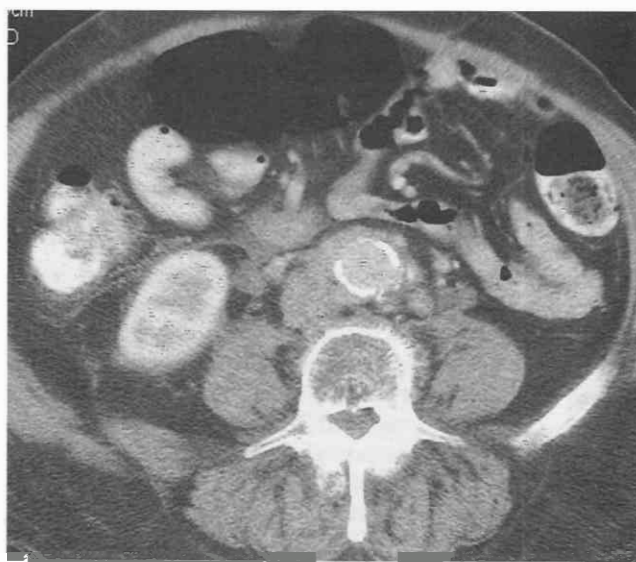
Retroperitoneal lymph node metastases mimicking retroperitoneal fibrosis. Contrast-enhanced CT scan demonstrates a conglomerate soft tissue mass of lymph nodes enlarged by tumor that surrounds the partially calcified abdominal aorta in a 75-year-old man with metastatic prostate cancer. The CT appearance is quite similar to that of retroperitoneal fibrosis.
